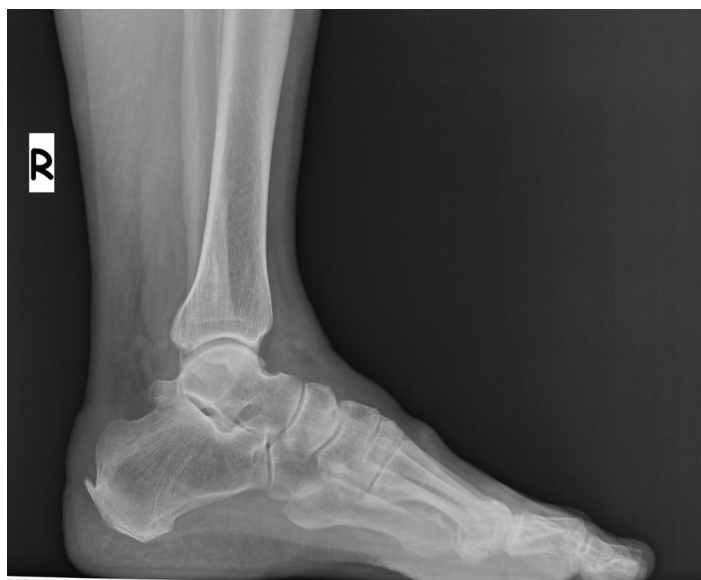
Preoperative standing lateral radiograph of a patient
